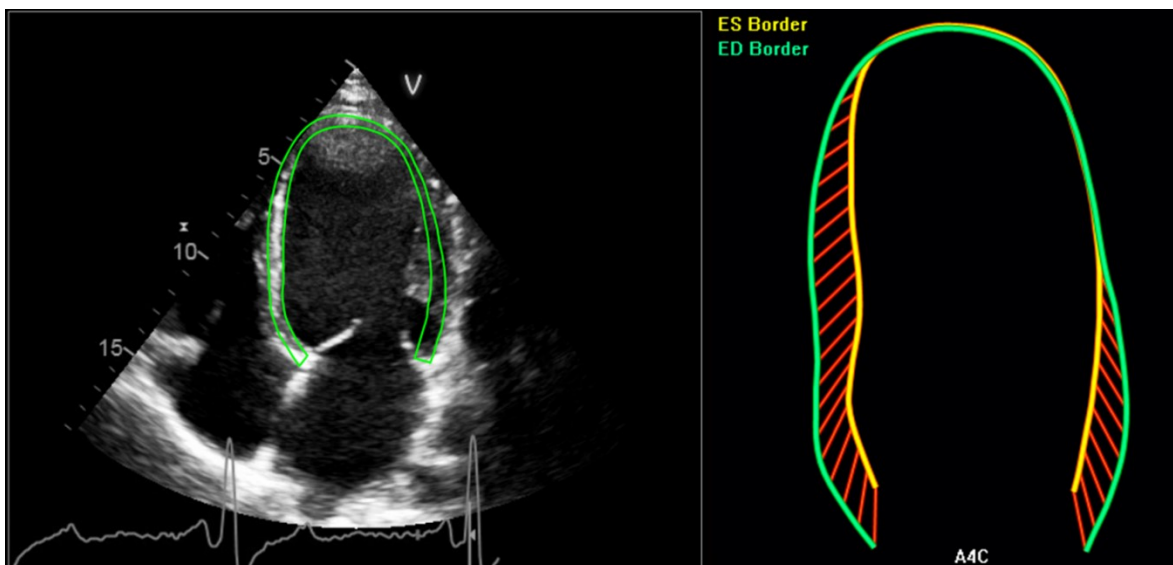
Example of endomyocardial contouring. Apical four chamber view in 2D-CPA, using the software TomTec.
